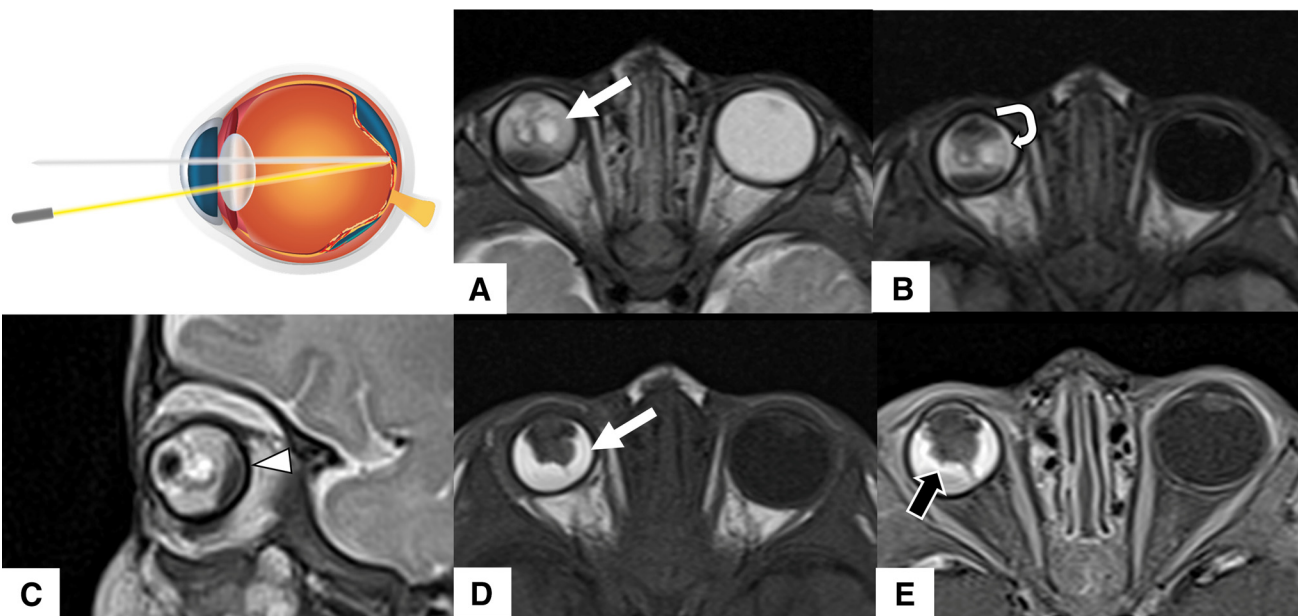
Coats disease of the right eye. Axial MR imaging sequences, T2 (A), FLAIR (B), sagittal T2 (C), T1 (D), and postcontrast T1 (E), show a subretinal exudate that is slightly hyperintense on T2 and T1 sequences (*white arrows*). This exudate remains hyperintense on FLAIR (*curved arrow*). After the administration of contrast, linear enhancement is identified in the periphery of the exudate, compatible with the enhancement of the detached retina (*black arrow*). A blood-fluid level is seen (*arrowhead*) on the sagittal image. On all sequences, the smaller size of the right eyeball can be appreciated.
